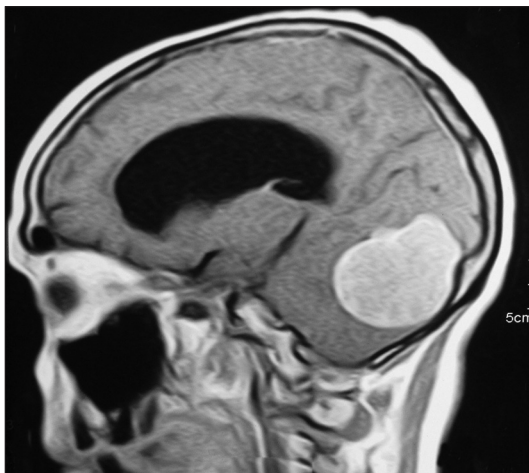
Preoperative MRI axial cut T1-weighted contrast image shows ventroinferior displacement of cerebellum and brainstem
